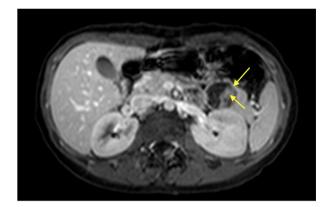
Axial contrast-enhanced arterial phase fat-saturated T1-weighted MR image: Well-defined pancreatic tail lesion with enhancing soft tissue component, as well as few enhancing septations (arrows). No connection with the pancreatic duct was seen in the MRCP images (not shown). No MRI evidence of malignant transformation was found, and there was no evidence of abdominal metastatic disease.
